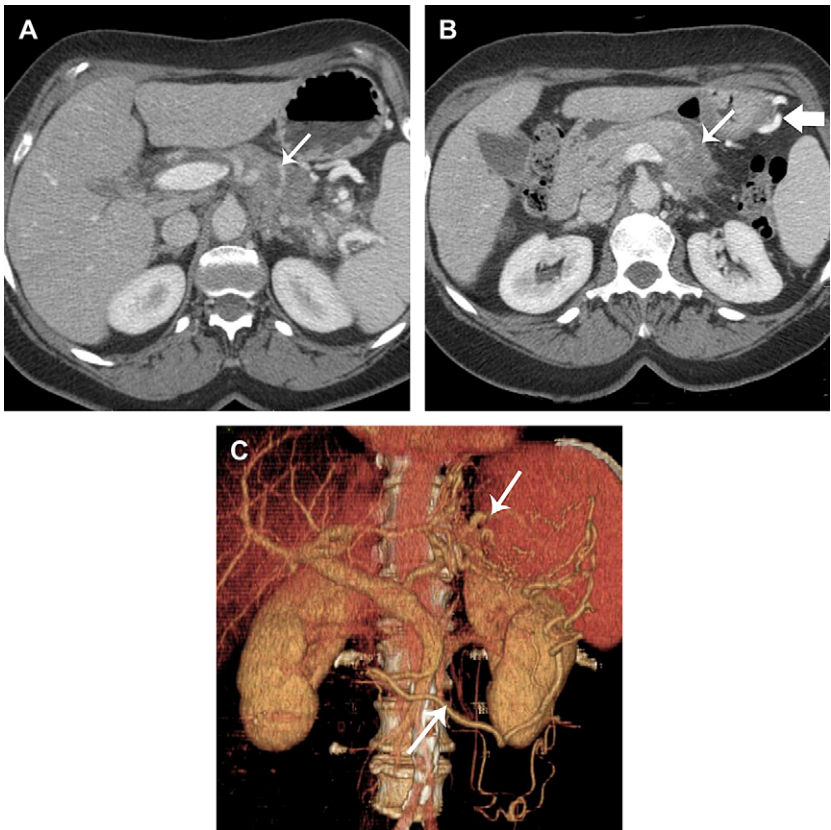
Sixty-year-old man who has unresectable pancreatic body carcinoma. (A) Axial CT scan shows a hypodense mass in the pancreatic body (arrow) that encases the celiac artery and its branches. (B) Note the interface between the hypodense tumor (thin arrow) and the normally enhancing pancreatic neck, just ventral to a patent portion of the distal splenic vein. Also note the venous collaterals (thick arrow) surrounding the stomach. (C) Three-dimensional reformation of CT data shows a patent superior mesenteric and portal vein but no splenic vein opacification. Multiple collateral veins (arrows), including short gastric and gastroepiploic, are noted.
